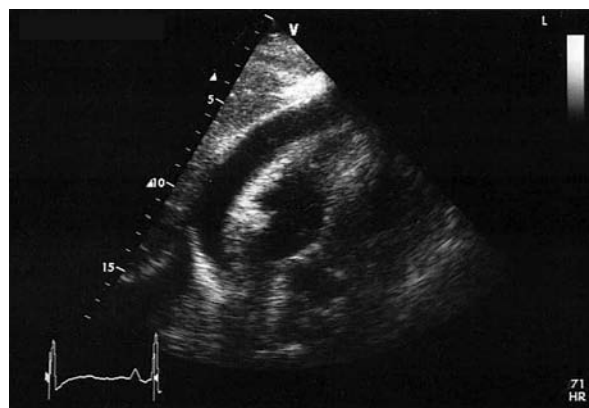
Echocardiography shows moderate-to-severe pericardial effusion without evidence of cardiac tamponade.
